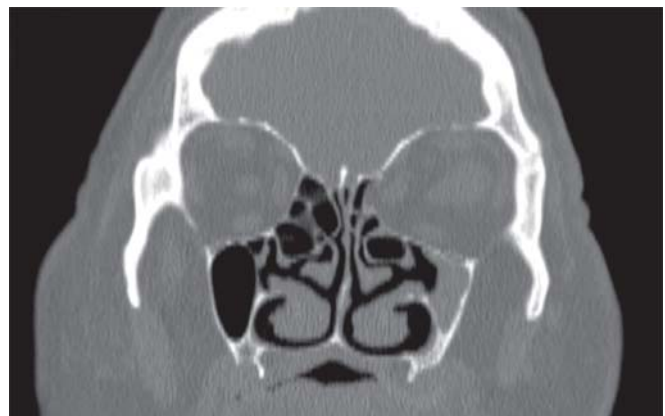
Coronal section of CT scan paranasal sinuses showing gross inward collapse of the bony walls of the left maxillary antrum. There is marked concavity of the medial wall of the maxillary sinus with evidence of complete bony resorption, with possible hyperostosis of the lateral antral wall. There is a large notable Haller cell on the left, which may contribute to ostial obstruction and subsequent hypoventilation of the maxillary sinus
